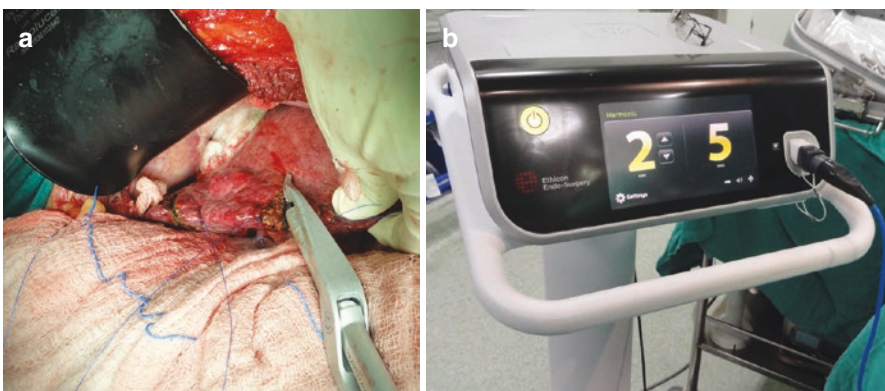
(a) Ultrasonic scalpel in liver resection. (b) Ultrasonic dissection machine
